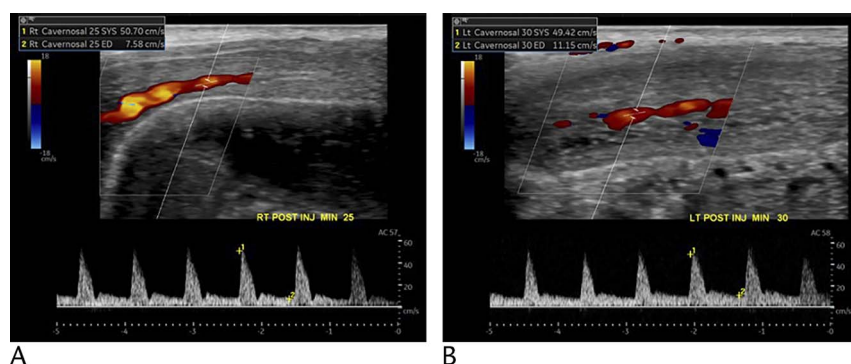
A 63-year-old man with erectile dysfunction. Sagittal spectral Doppler images from 25 (A) and 30 (B) minutes after prostaglandin injection showing an end-diastolic velocity within the corpus cavernosal artery of 7.6 and 11.5 cm/s, respectively, consistent with venous leakage.
